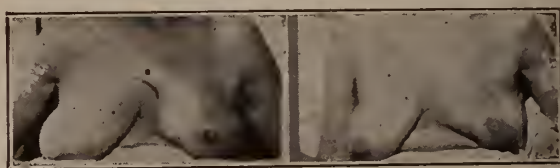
(a) 3/12/21. Carcinoma of left breast. Duration one year. Palpable metastatic glands. (b) Complete disappearance of all tumor tissue following general deep Roentgentherapy over the glandular areas, and the insertion of radium needles locally into the tumor tissue. Still well 4/17/21.
